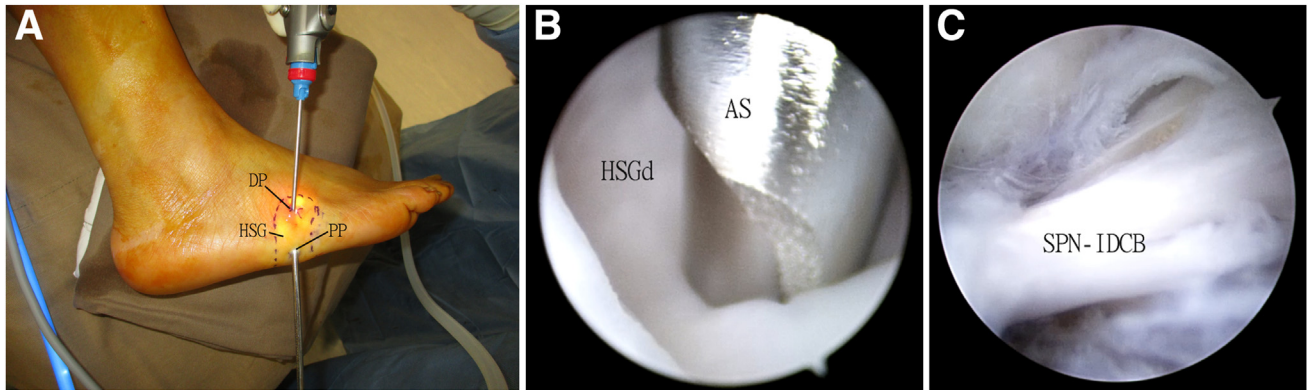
Endoscopic resection of horseshoe ganglion of the right lateral midfoot. The patient is in a lateral position. Magnetic resonance imaging shows the horseshoe ganglion spanned from dorsal to plantar side of the lateral midfoot. (HSG, horseshoe ganglion.)
